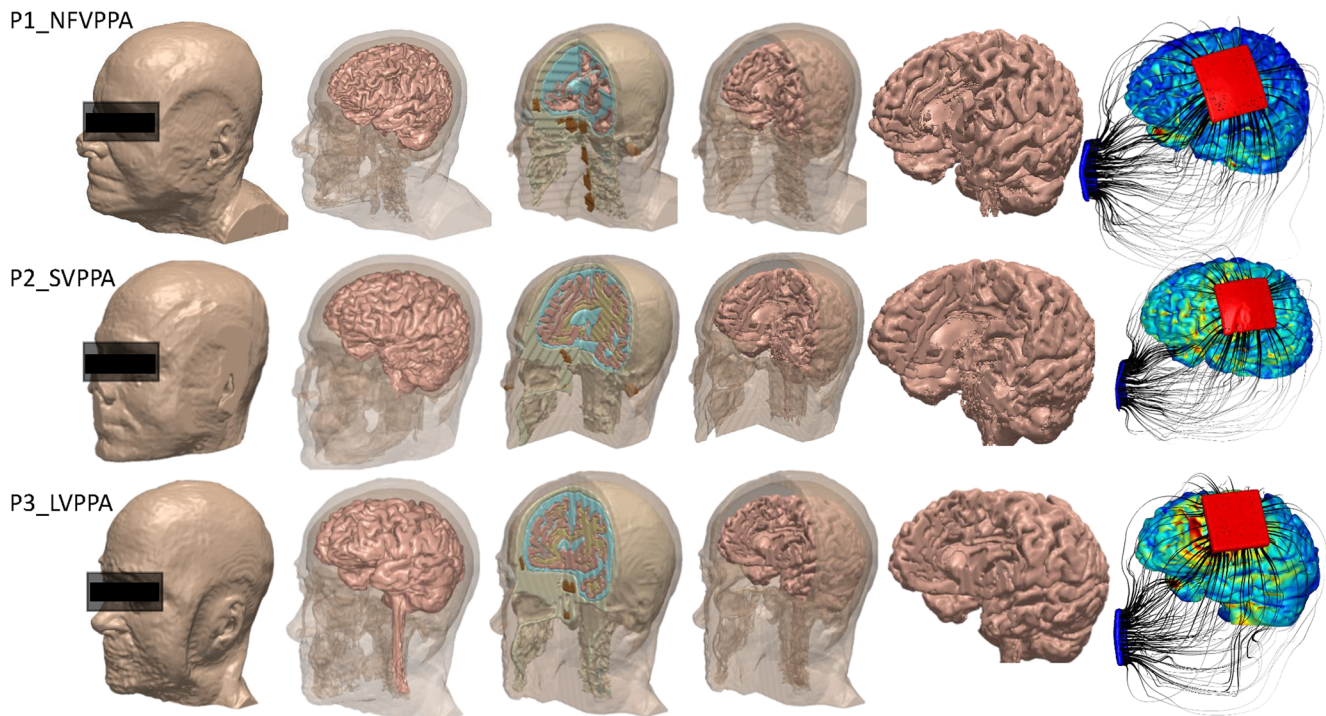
High-resolution tDCS modeling in primary progressive aphasia (PPA). T1- and T2-weighted sequence MRIs were collected at a resolution of 1 mm. Three subjects, each representing one variant of PPA, i.e., semantic variant PPA, non-fluent variant PPA, and logopenic variant PPA that have different patterns of atrophy, were segmented into six tissue
